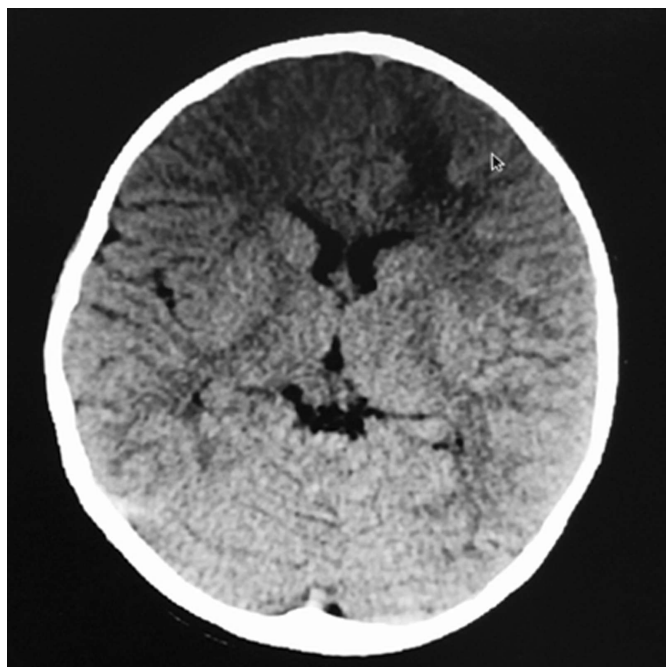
CT brain after 3 weeks showing decrease in size of hypodensity, edema and mass effect.
